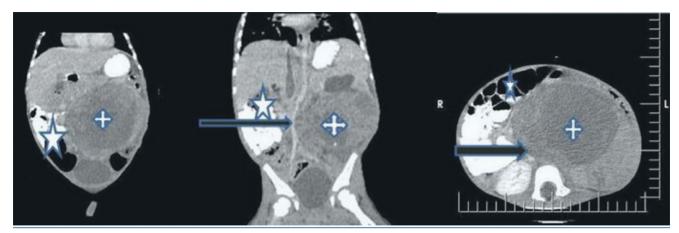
CT imaging of the abdomen and pelvis of a 3-year-old male patient. Axial (left and right) and coronal (center) views demonstrating left renal mass (white cross) with displacement of the abdominal aorta (black arrow) and bowel (white star). Reproduced with permission from Ikhouriah T, Oboh D, Yakubmiyer M, et al. Wilms tumor: a case report with typical clinical and radiologic features in a 3-year-old male. *Radiol Case Rep.* 2023;18(5):1898-1904.
